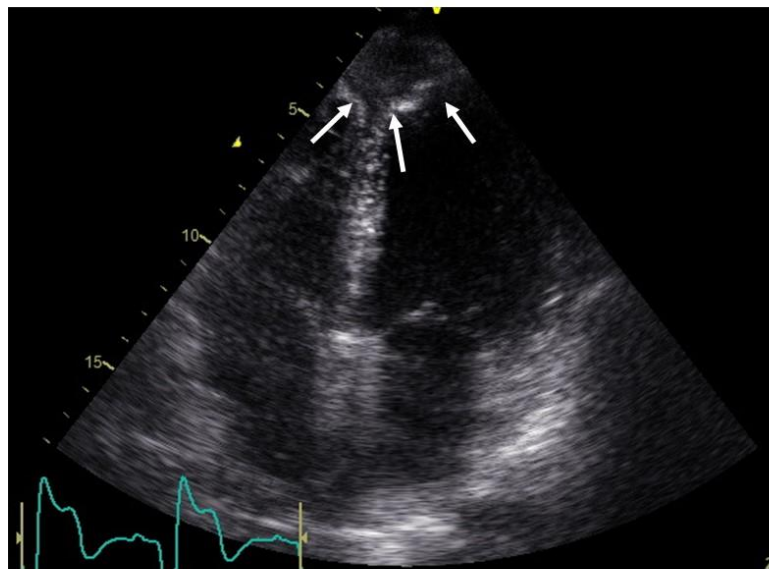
Transthoracic echocardiography (Apical 4 chamber view), showing apical epicardial mass, 21 by 33mm, a carcinoid metastatic lesion (White arrows).
